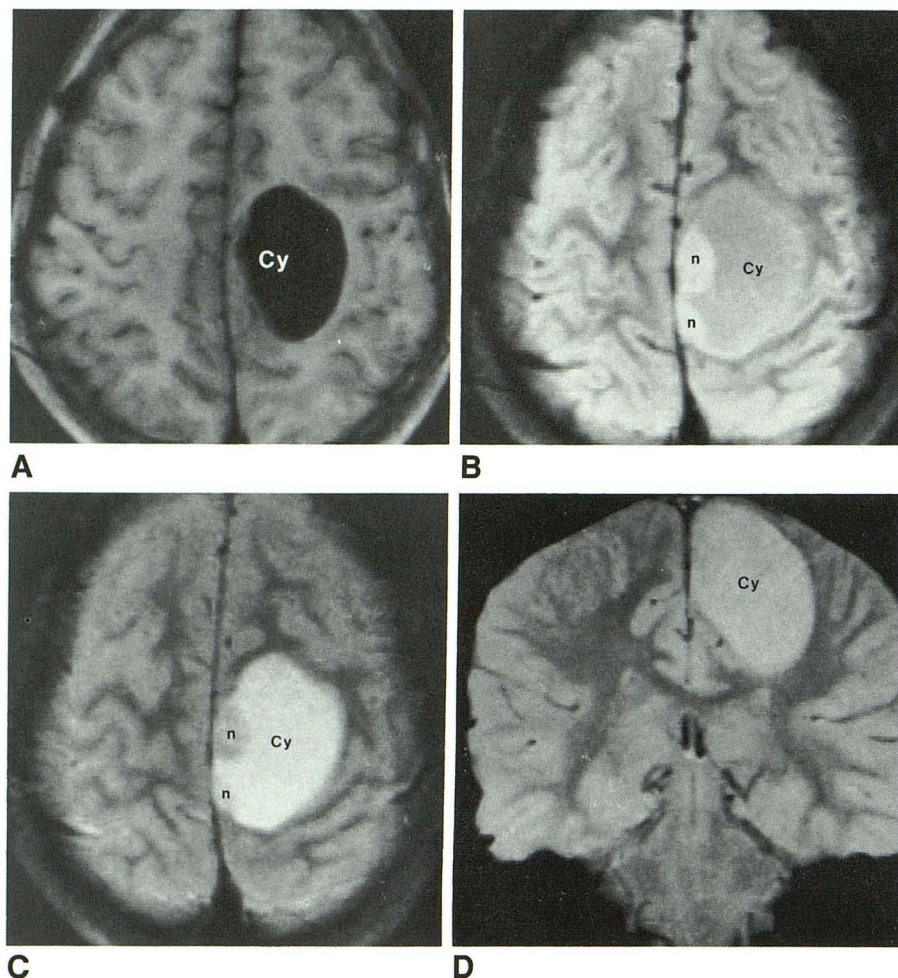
Case 8: 8-year-old boy with mixed cystic and solid ependymoma; MR images are at 0.35 T.
